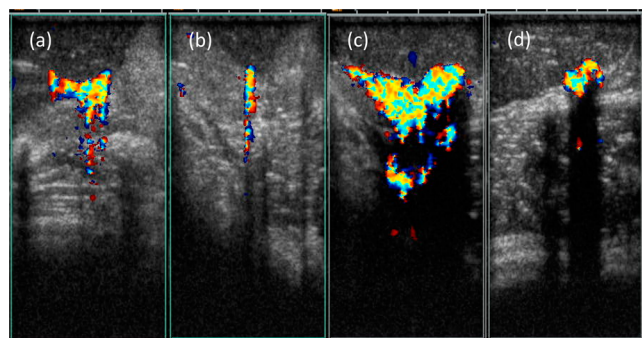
Color Doppler signals of macrophase-separated PMCA/microshells film coated surgical tools in a live rabbit. Surgical needles (a, b), umbilical tape (c), and surgical clip (d) in the abdomen of a live rabbit, imaged with the 15L8 transducer and US frequency of 7 MHz.
